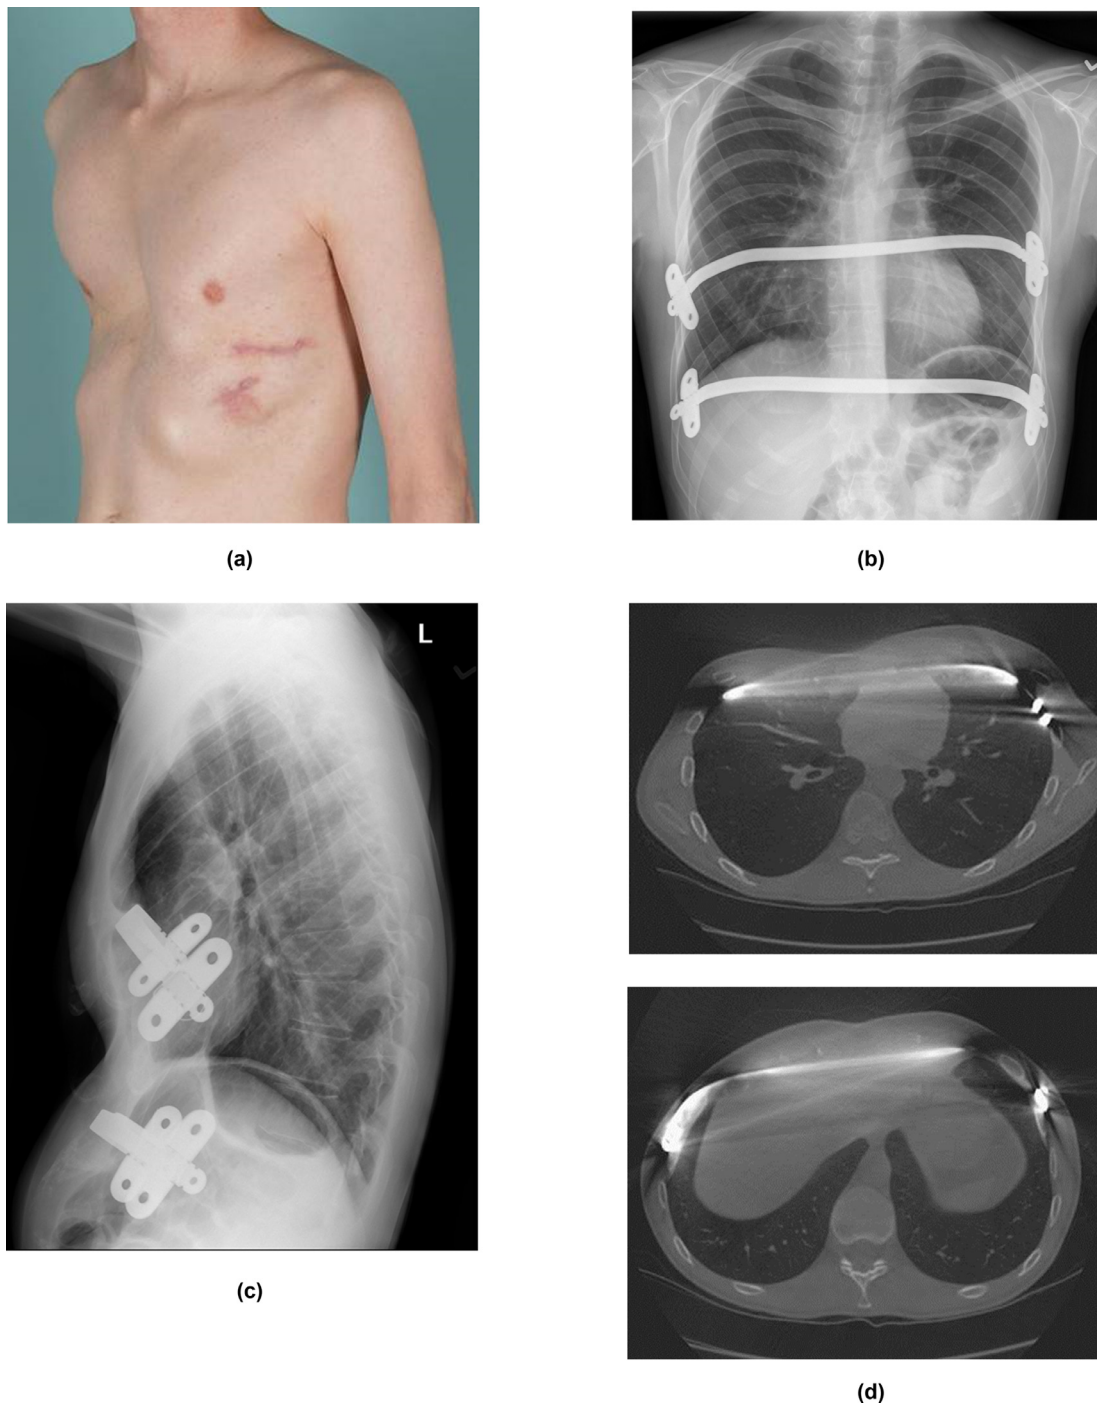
(a) A 35-year old male presented for evaluation after undergoing MIRPE at an outside institution. On evaluation he had residual pectus deformity despite 2 indwelling support bars. His chest imaging confirmed failed MIRPE due to posterior-lateral migration of pectus support bars. (b) PA chest x-ray shows 2 Nuss bars with bilateral stabilizers (c) lateral imaging is critical to reveal rotation of the bars with residual pectus defect (di, ii) CT images confirm both pectus support bars with lateral intercostal exit and failure to contact the sternum for anterior elevation.
